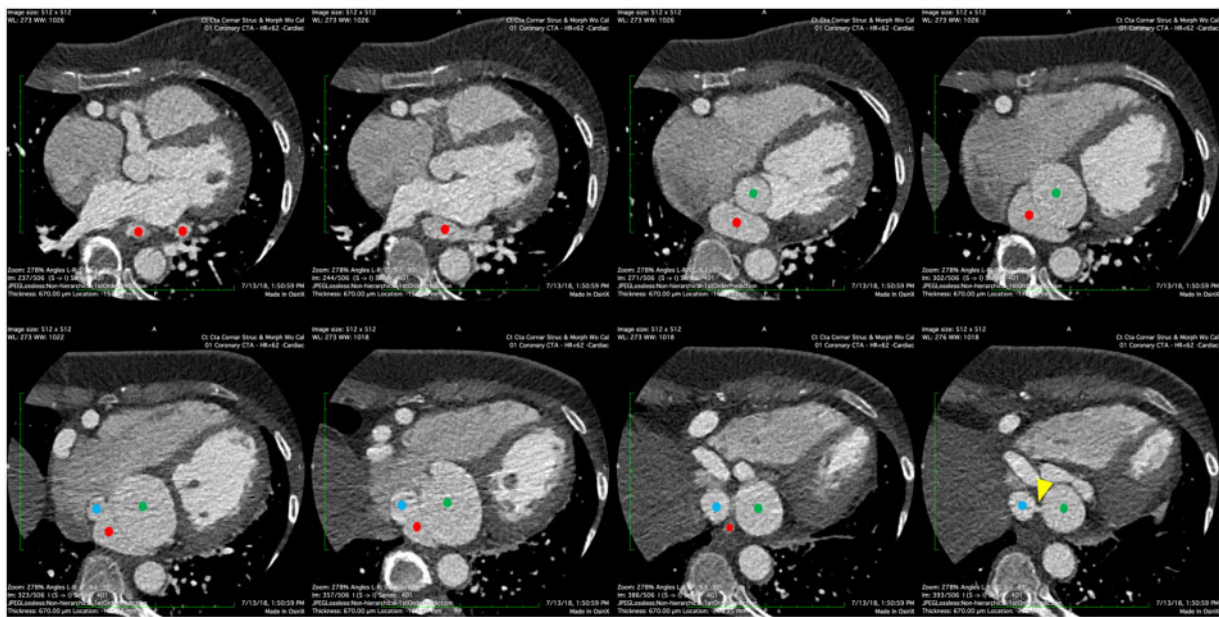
Craniocaudal computed tomography sequence demonstrating 1st pseudochamber (red), 2nd pseudochamber (green), and 3rd pseudochamber (blue) of the fistula. A narrow neck connected the 2nd and 3rd pseudochambers (arrowhead).
